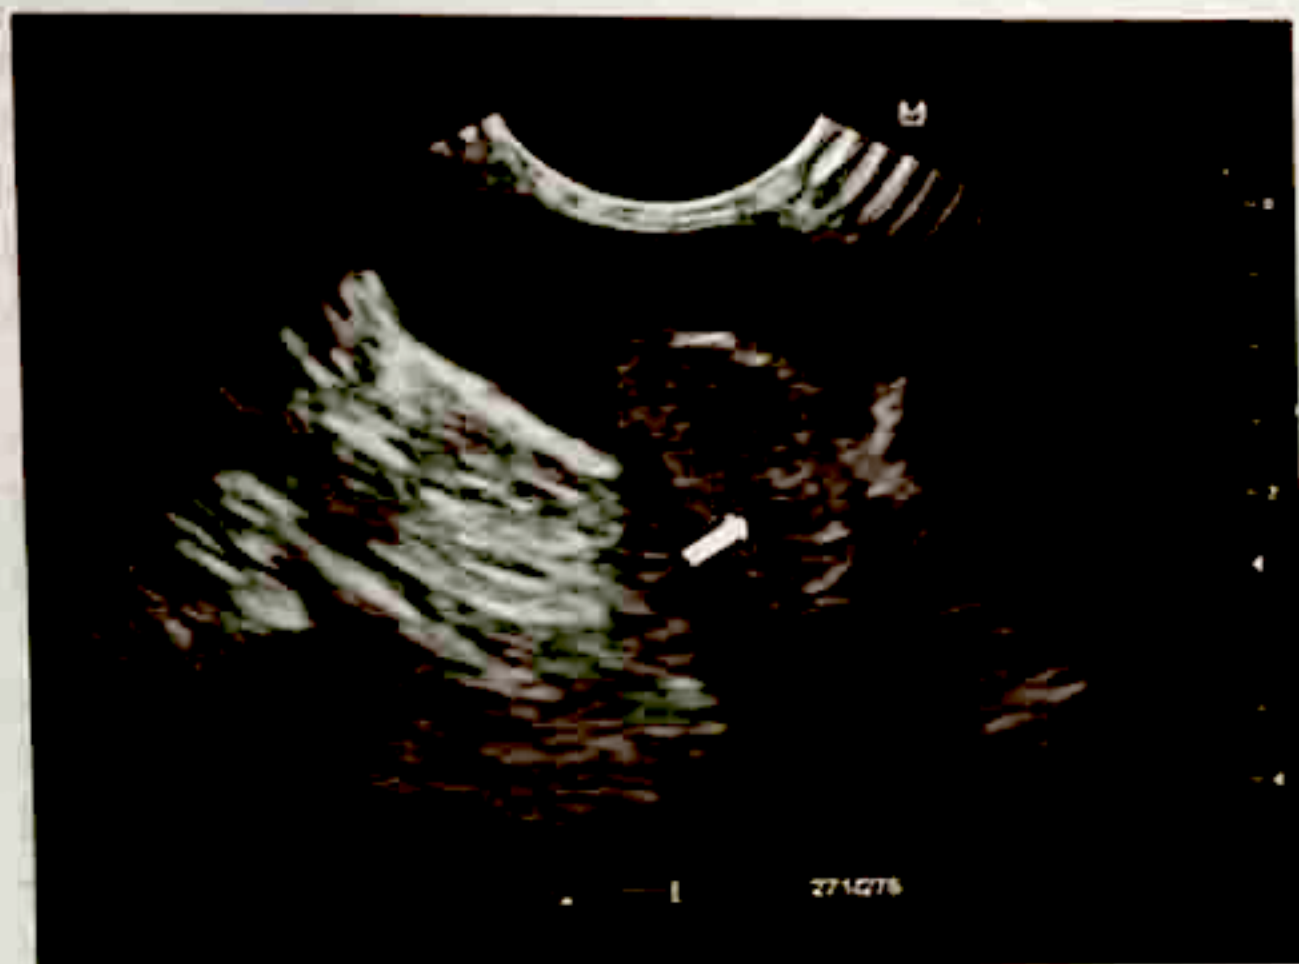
Transperineal ultrasound showing the right gonad within the labioscrotal fold.
